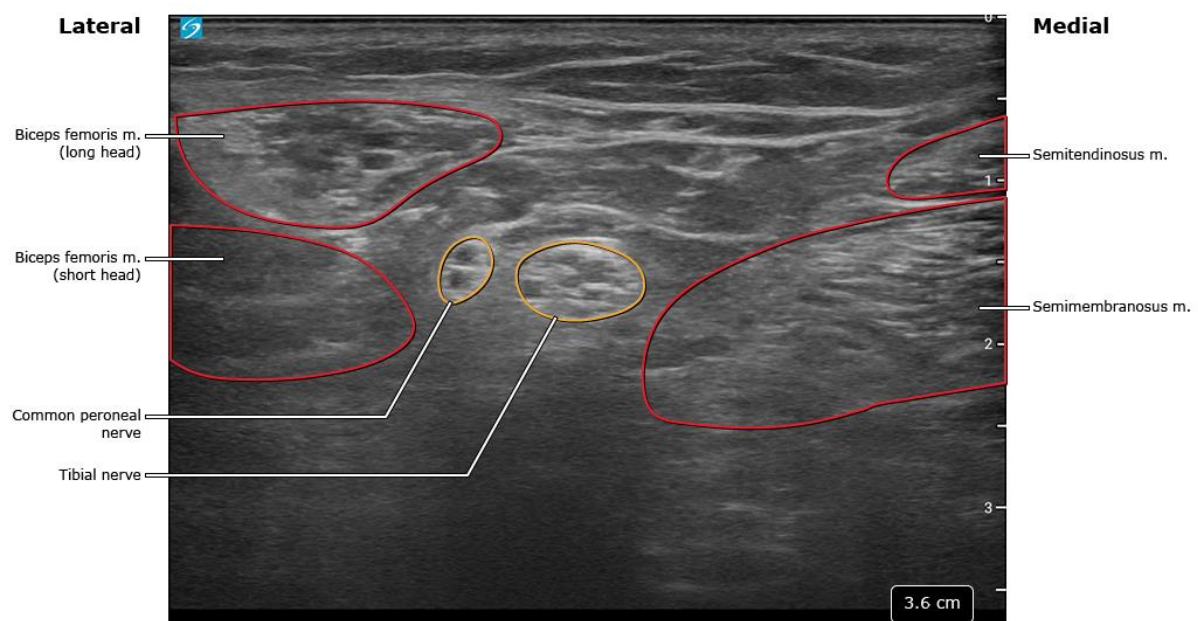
Ultrasound for popliteal block
